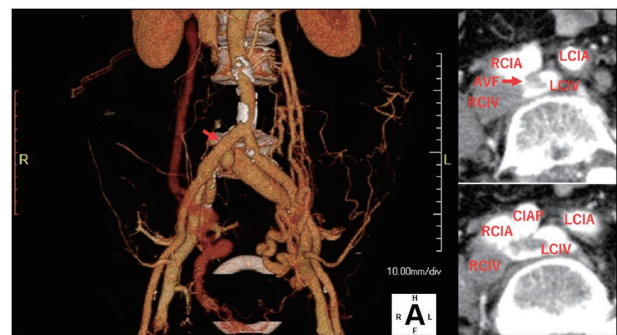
Contrast-enhanced computed tomography revealed an ilio-iliac fistula between the right common iliac artery and left common iliac vein. An aneurysm was observed just internal to the AVF.
